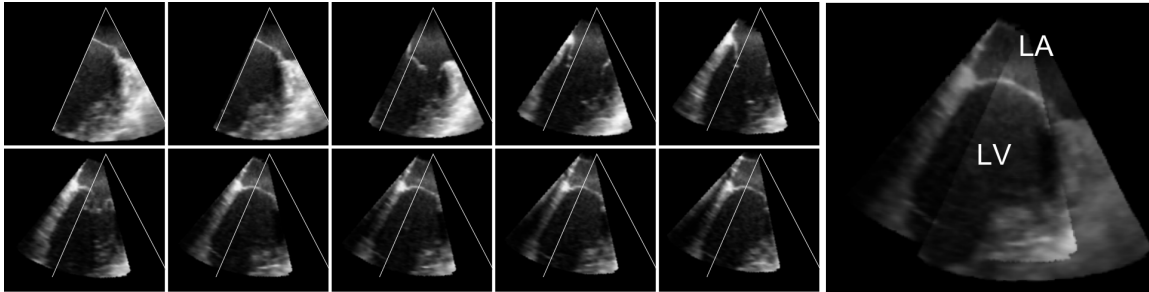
(*Small images on left*) Stabilized (registered) images from a live 3DUS sequence of the beating heart (in order from left to right and top to bottom) acquired while rotating the transesophageal probe. The white lines show the location of the first frame relative to the stabilized frame. (*Large image on right*) An overlay of gated images from before and after the probe was rotated, showing that the registration correctly stabilized the sequence. This also shows that the registration algorithm can handle small amounts of nonrigid deformation. (LA – left atrium, LV – left ventricle)
